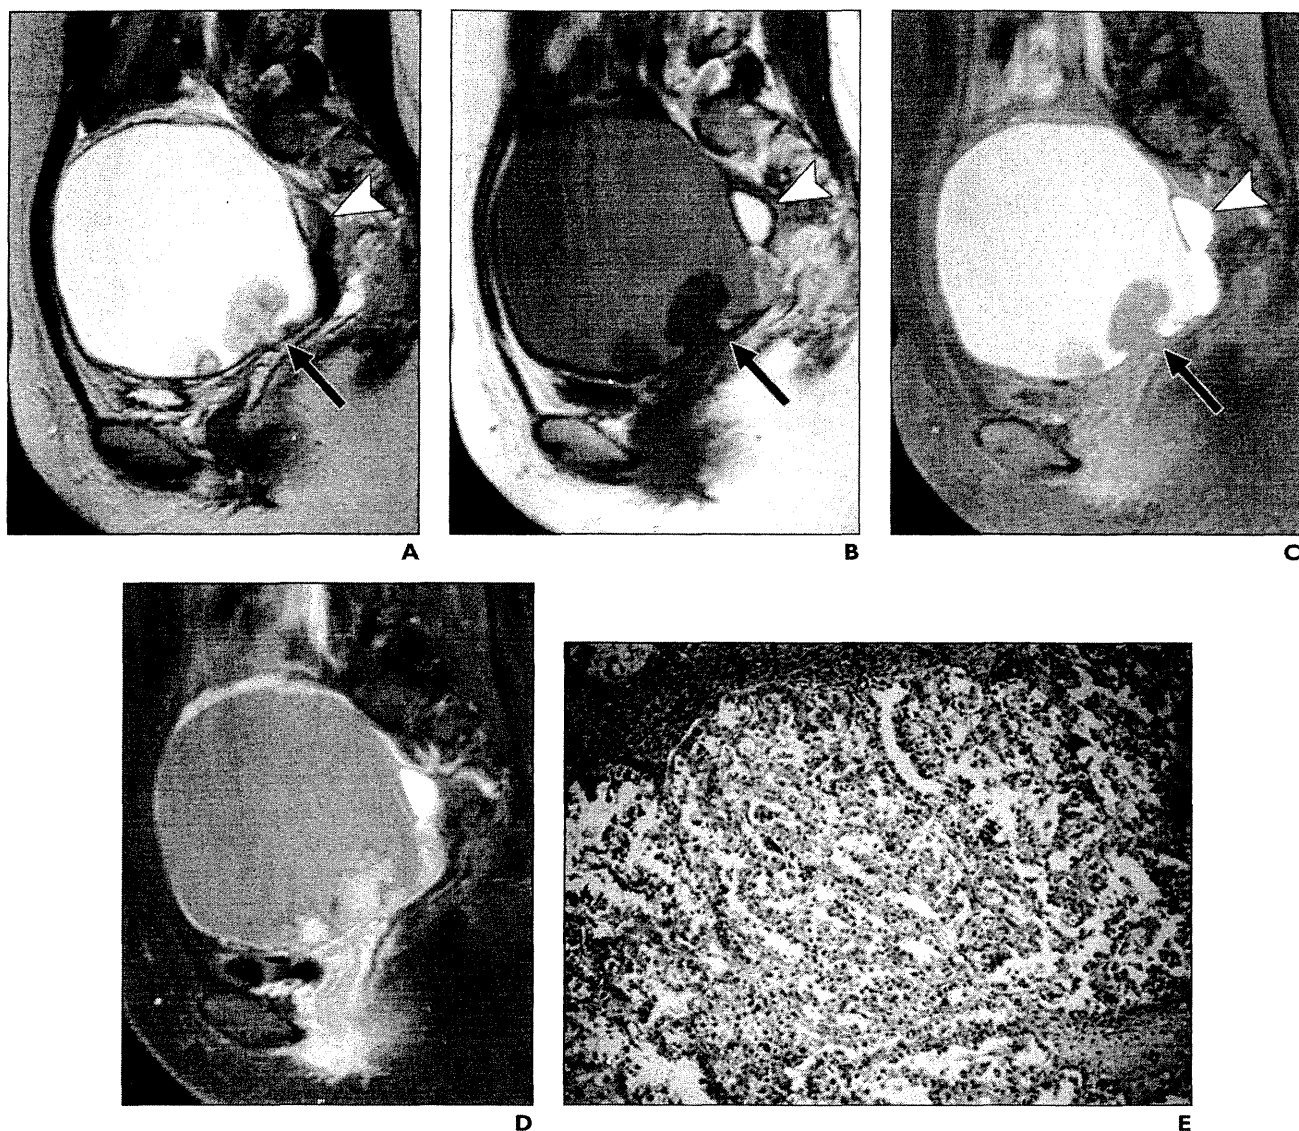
Clear cell adenocarcinoma arisen from endometriotic cyst of left ovary (International Federation of Gynecology and Obstetrics stage Ic) in 35-year-old woman. A–C, There are two cysts in pelvis: Larger cyst shows high signal on T2-weighted image (A) (TR/TE_{eff}, 1,800/100) and slightly high signal on T1-weighted image (B) (TR/TE, 594/10). Signal was not suppressed by fat-suppressed T1-weighted image (C) (680/10). There are two papillary projections (*arrows*) on floor of cyst that show high signal on T2-weighted image and low signal on T1-weighted image. We can also see another cyst (*arrowheads*) that is diagnosed as typical endometriotic cyst in contralateral ovary. It shows high signal intensity on T1-weighted images and diffusely low signal intensity on T2-weighted image in endometriotic cyst with malignancy.
